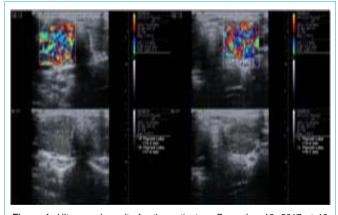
Ultrasound results for the patient on December 12, 2017 at 16 months of age with thyroid lobe measurements noted in the upper images. Lower images represent corresponding arterial vascularization for each thyroid lobe.
